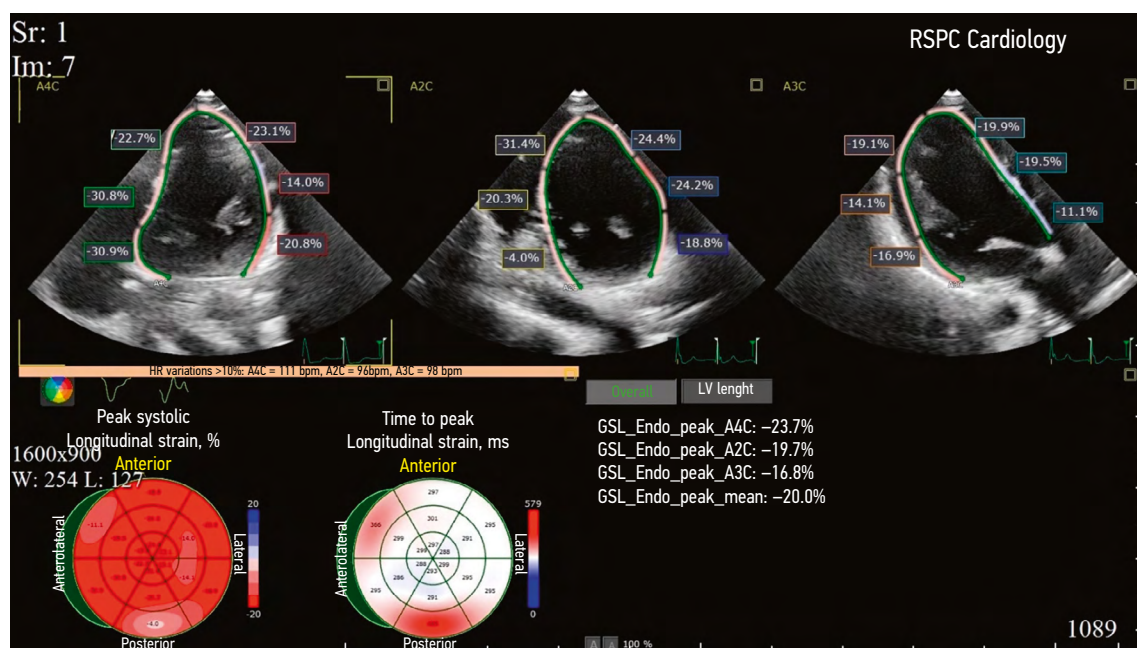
Two-dimensional strain echocardiography of patient K. Left ventricular global longitudinal strain (-20.0%).
